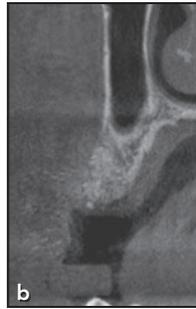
(a) Intraoral radiograph after 5 months of healing. The lamina dura is no longer visible, and the former dentin graft has the same appearance of the surrounding bone tissue. (b) Cone beam computed tomography evaluation after 5 months of healing. The buccal plate has been resorbed, and the marginal ridge remodeling has been compensated by the ridge preservation procedure.
